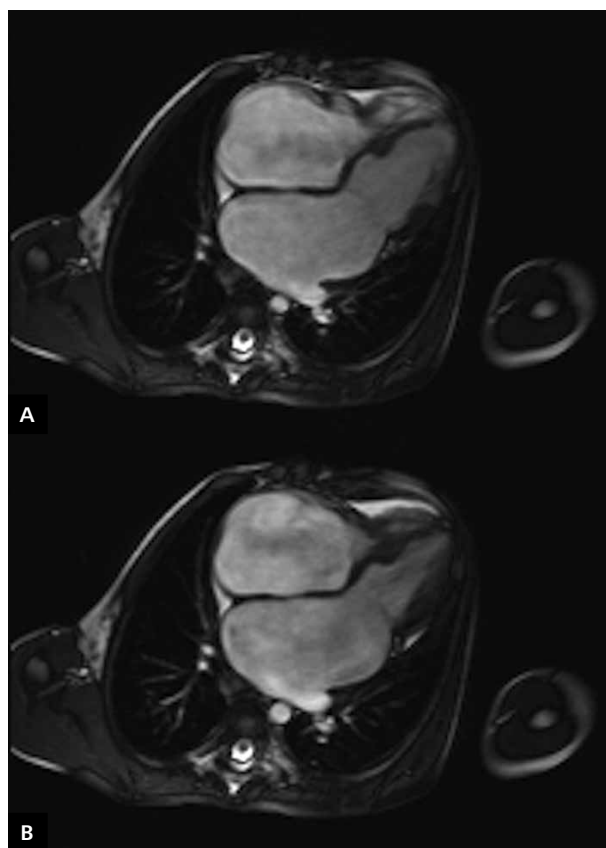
Cardiac magnetic resonance images in a patient with restrictive cardiomyopathy. Severe left and right atrium dilatation is demonstrated, as well as normal left and right ventricular diameters and systolic functions; A. Four-chamber view, cine SSFP sequence. End-diastole; B. Four-chamber view, cine SSFP sequence. End-systole
